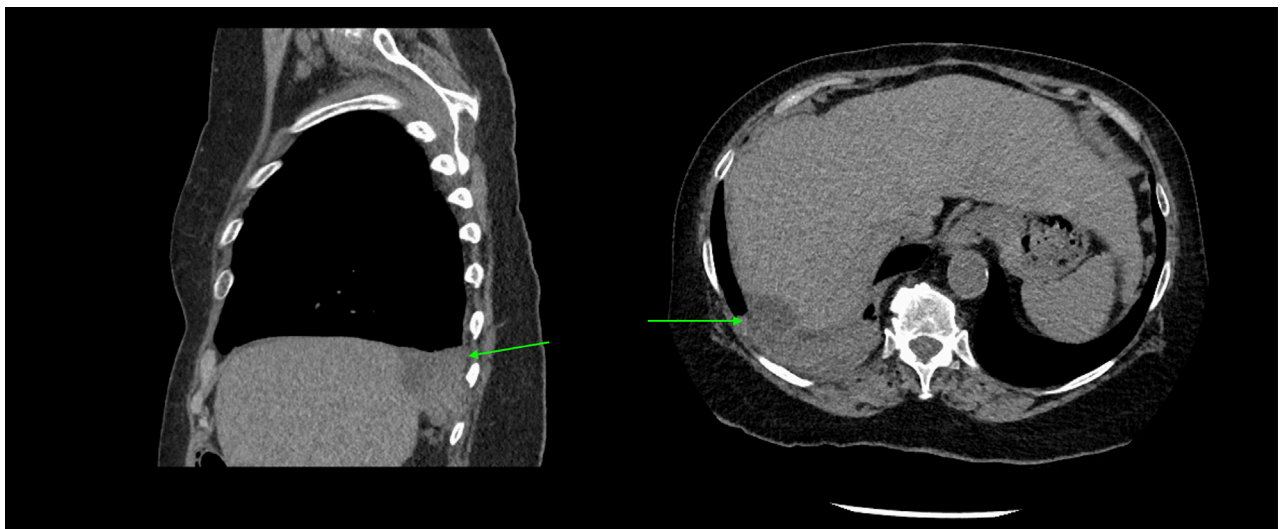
Sagittal (left) and Axial (right) Computed Tomography Without Contrast Showing Direct Spread of Right-Sided Pyogenic Liver Abscesses Into Lung Parenchyma and Formation of an Empyema (green arrows)
